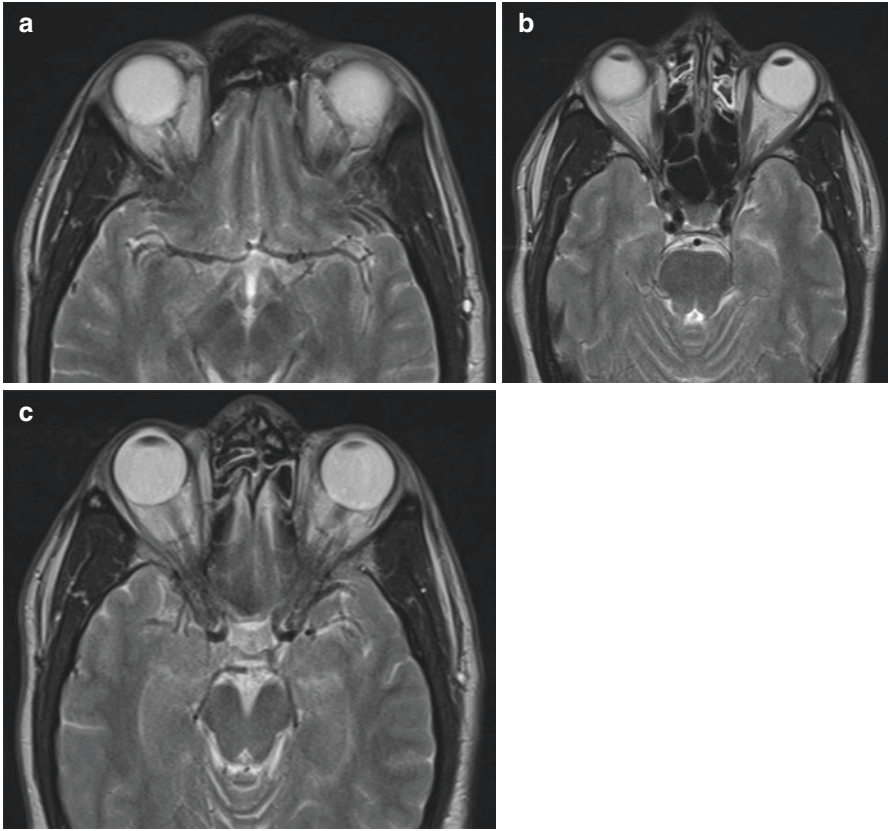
(a–c) MRI is very useful in evaluating globe/orbital pathology
